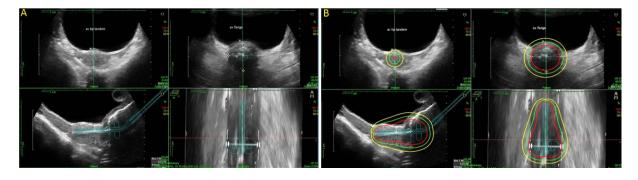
Ultrasound imaging and planning
